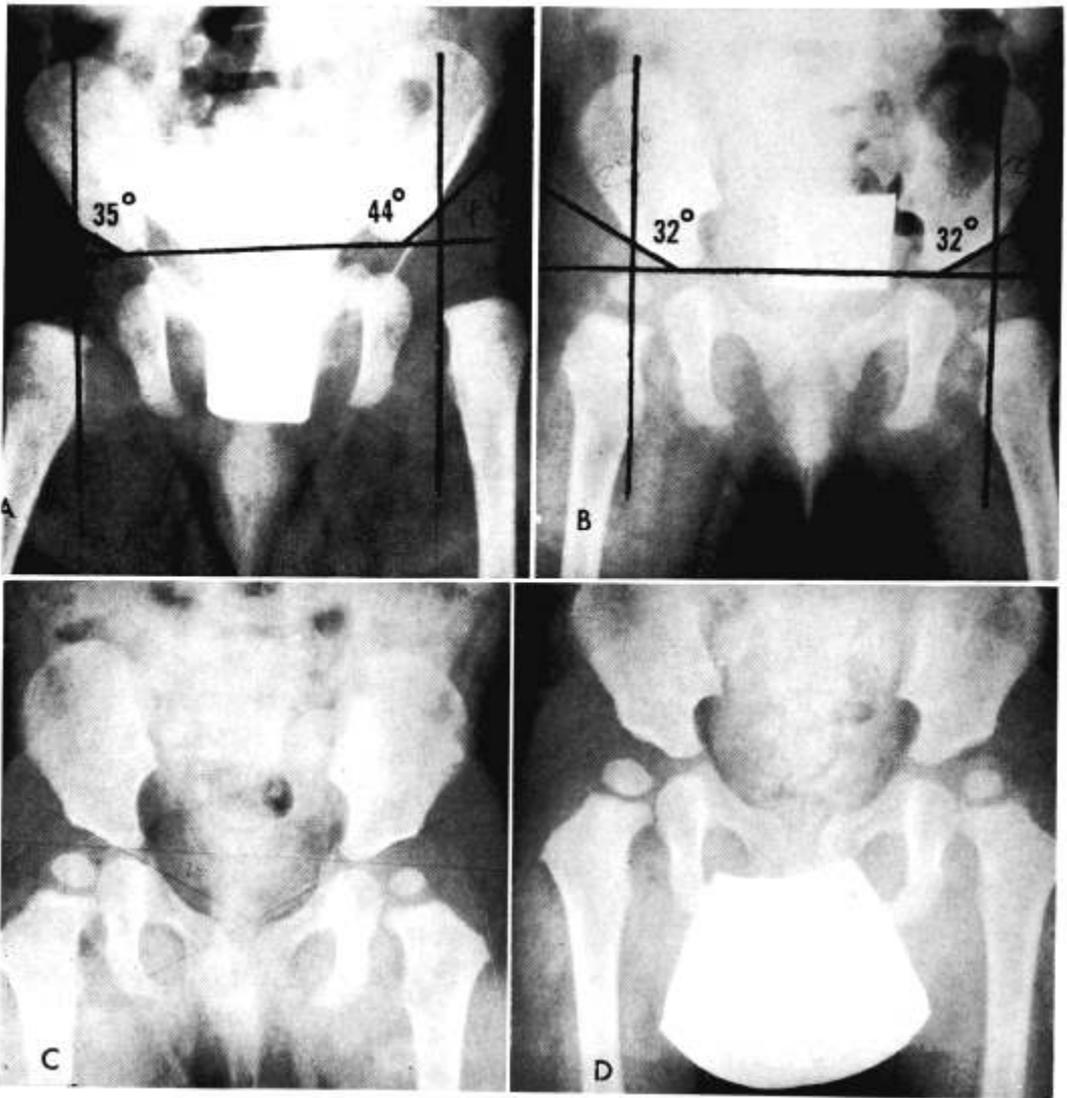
Case 4. The left hip on this female infant could be displaced readily from the socket when first examined at 6 weeks of age. The roentgenogram (A) was taken at 3 days of age and shows an abnormal acetabular index (44°), lateral disposition of the femoral "beak" and equivocal shortening of the "H" line on the left. Prescribed splinting was discarded for the more practical cradle board. (B) Taken at age 6 months, and (D) at 15 months. Though showing steady improvement through 9 months, the roentgenogram at 15 months shows failure of further improvement and retention of dysplastic features.
